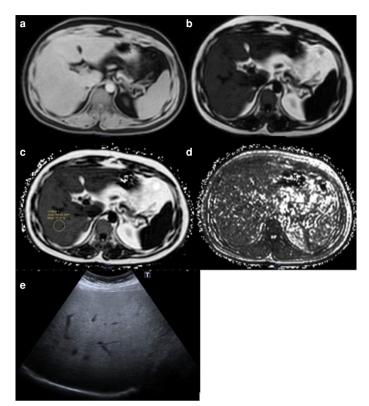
Axial section of MR mDixon-Quant and ultrasound scan of a 47-year-old male patient. (a) Water Value: 1019.04, (b) Fat Value: 273.84, (c) Fat Percentage: 21.16%, (d) T2* Value: 24.94 ms, (e) Ultrasonographic findings reveal Grade 2 hepatic steatosis.
